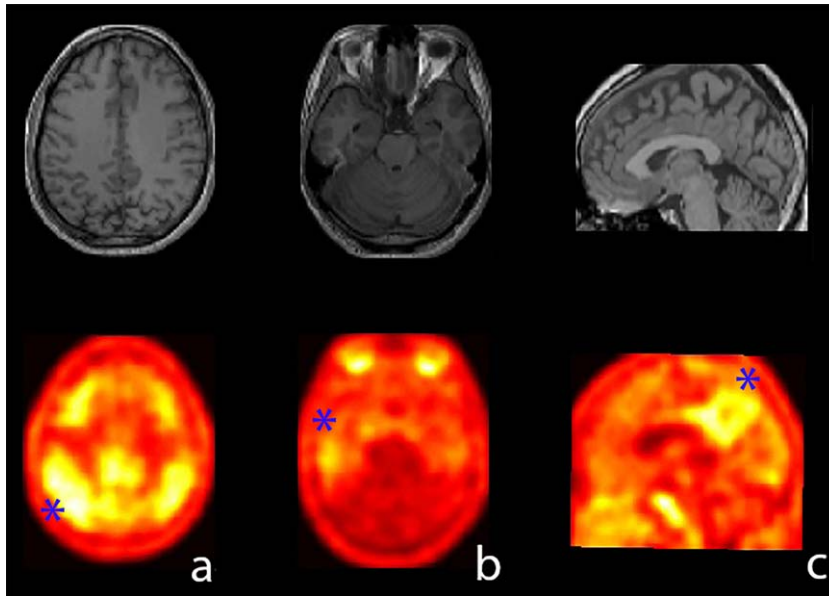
Exemplification case 2. Co-registered PET imaging (bottom) with a template MRI (top) showing a significant increase of tau burden in the parietal (a, blue asterisk) and temporal (b, blue asterisk) cortex presented in axial view. A detail of the parietal cortex showing the right precuneus burden is provided in (c, blue asterisk).
